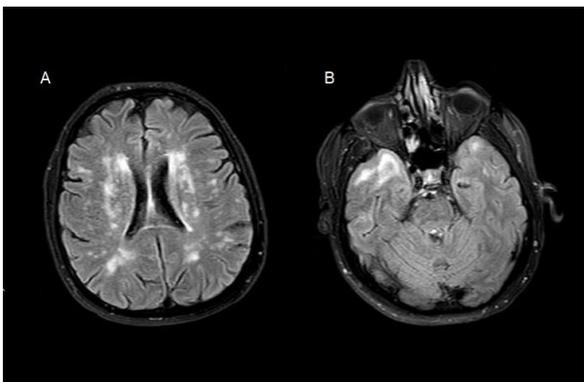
Fluid-attenuated inversion-recovery (FLAIR) showed high-intensity signal changes in the bilateral subcortical white matter predominantly involving the external capsule (2A) and temporal poles (2B).
